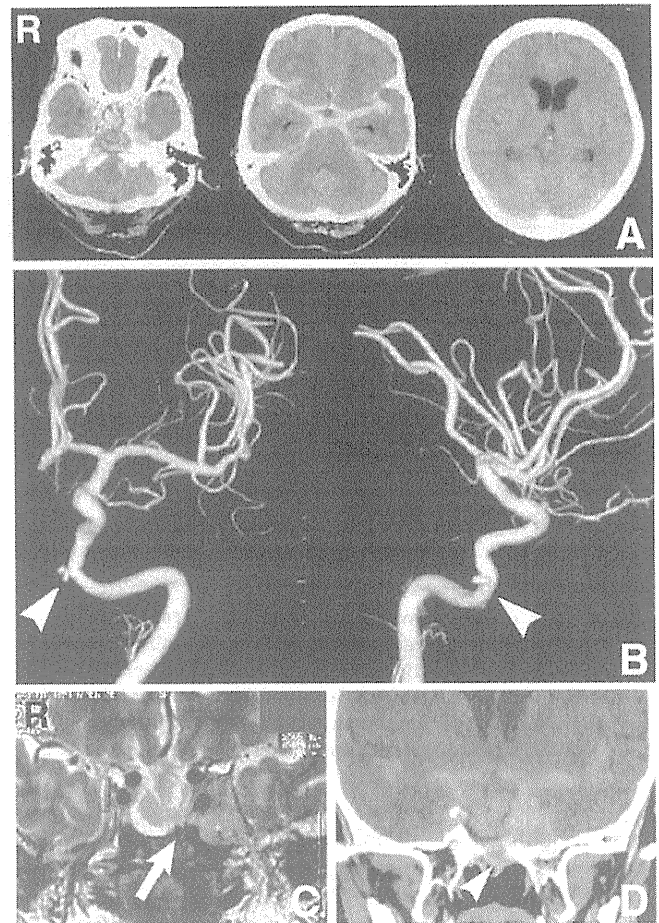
Neuroradiological findings of 2009 hospitalization. A: Initial computed tomography (CT) scans demonstrating subarachnoid hemorrhage (SAH) predominantly located in the basal cistern and empty sella. B: Left internal carotid angiograms, anteroposterior (left) and lateral (right) views, demonstrating the petrous internal carotid artery (ICA) aneurysm and adjacent stenotic segment of the left petrous ICA (arrowheads). C: Coronal T₂-weighted magnetic resonance image showing the aneurysm (arrow) located at the boundary between cisternal space and sphenoid sinus. D: Coronal CT scan showing the SAH leaking into the nasal sinus through the skull base defect (arrowhead).
